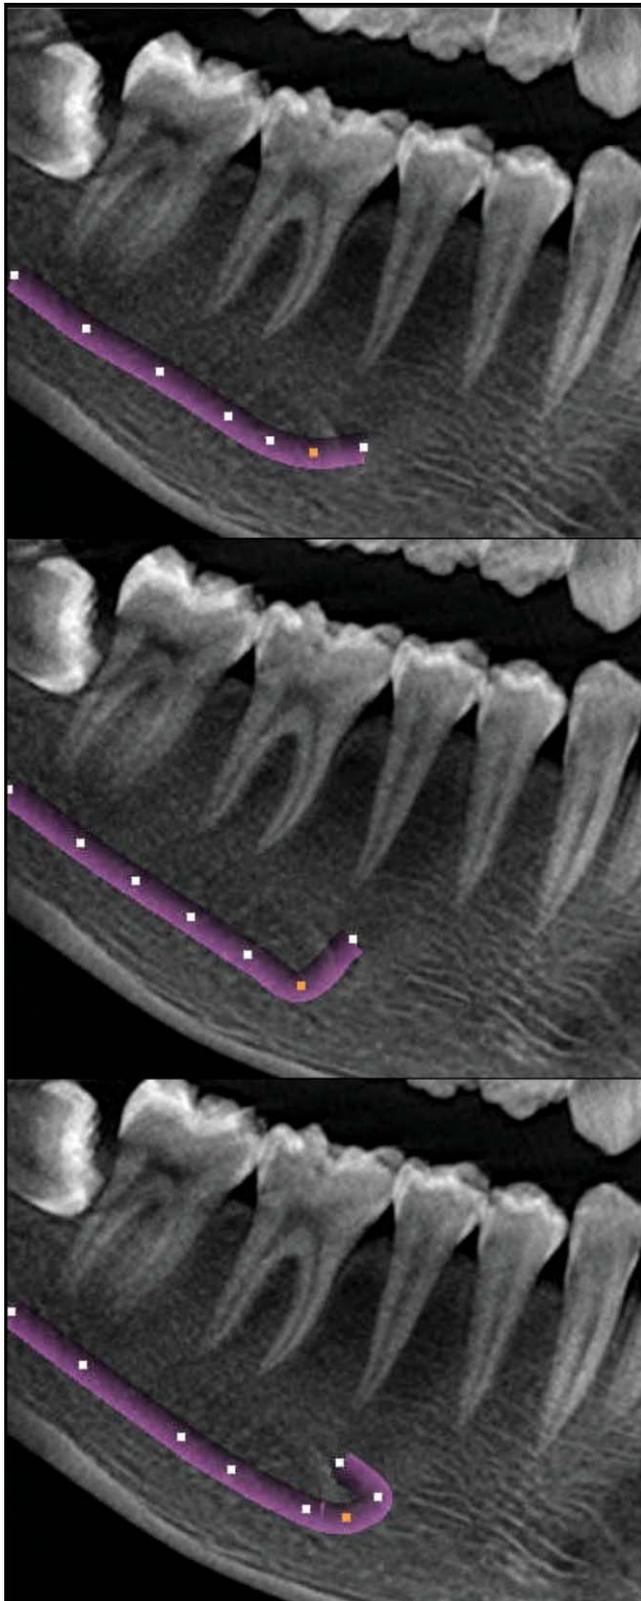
Mandibular nerve configuration on cone-beam computed tomography (CBCT). A: Linear, B: Perpendicular, C: Anterior loop.
